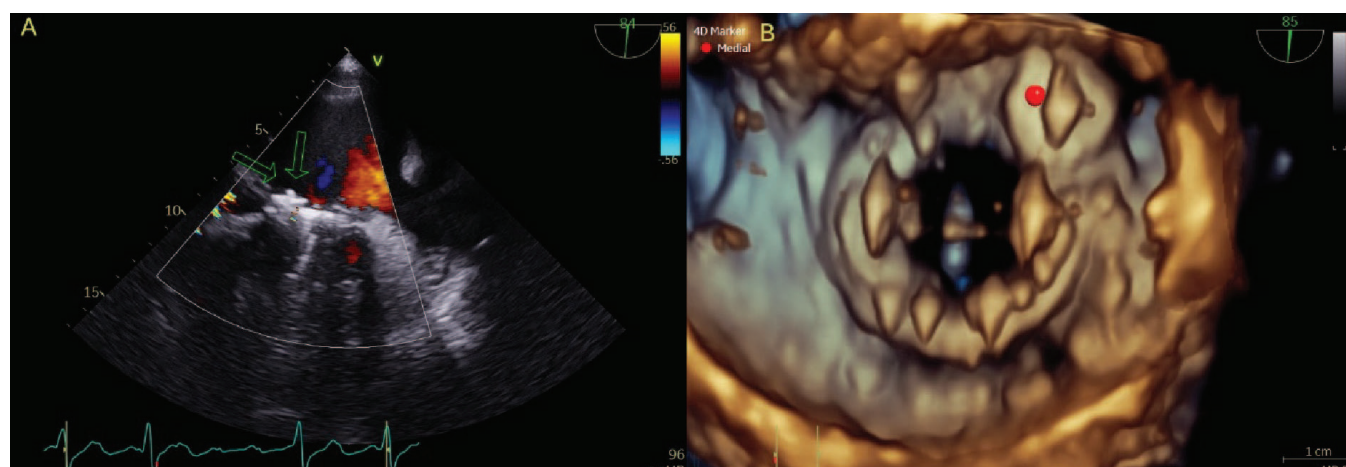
A) Postprocedural transesophageal echocardiography (TEE) showing good results with only a trace of residual paravalvular leak. B) 3D reconstruction of TEE appearance of the Amplatzer Vascular Plug III (indicated with the red dot).
